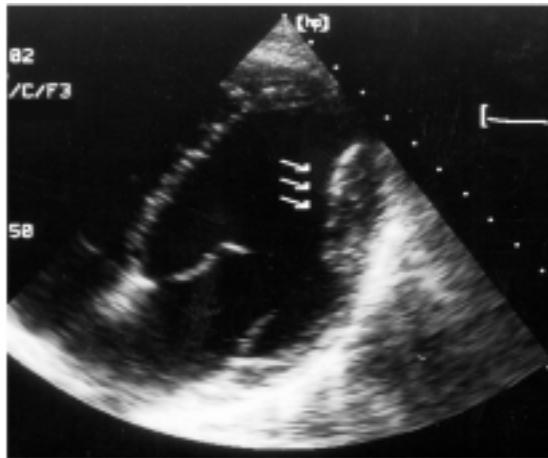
Apical four-chamber-view echocardiogram. Distribution of hypertrophy is virtually confined to the middle and apical segments of lateral free wall (LFW) in the left ventricle (arrows). Note that the anterior ventricular septum and basal segment of LFW are of normal thickness.
